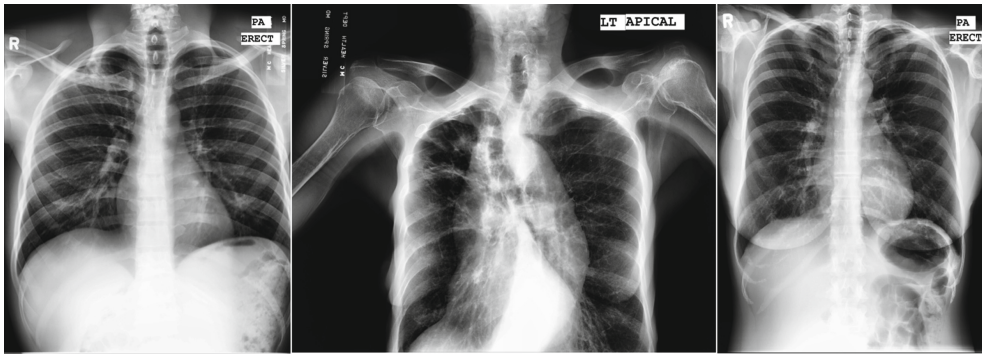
Samples of the enhanced chest X-ray
